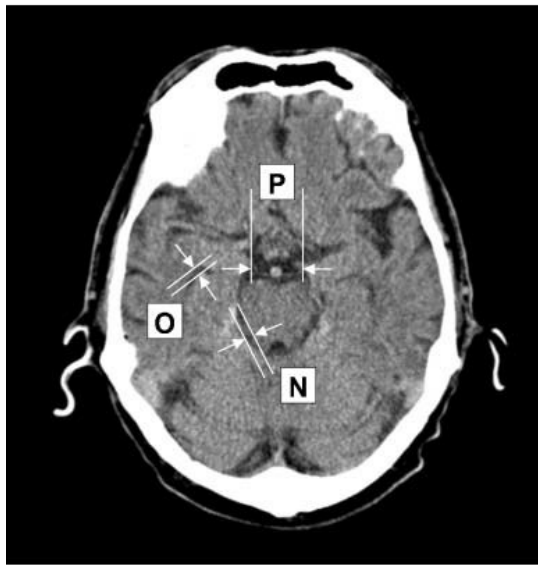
Linear measurements taken on axial CT slices Reproduced with permission from Acta radiologica (SAGE publications –see appendix 9 for permission information)
